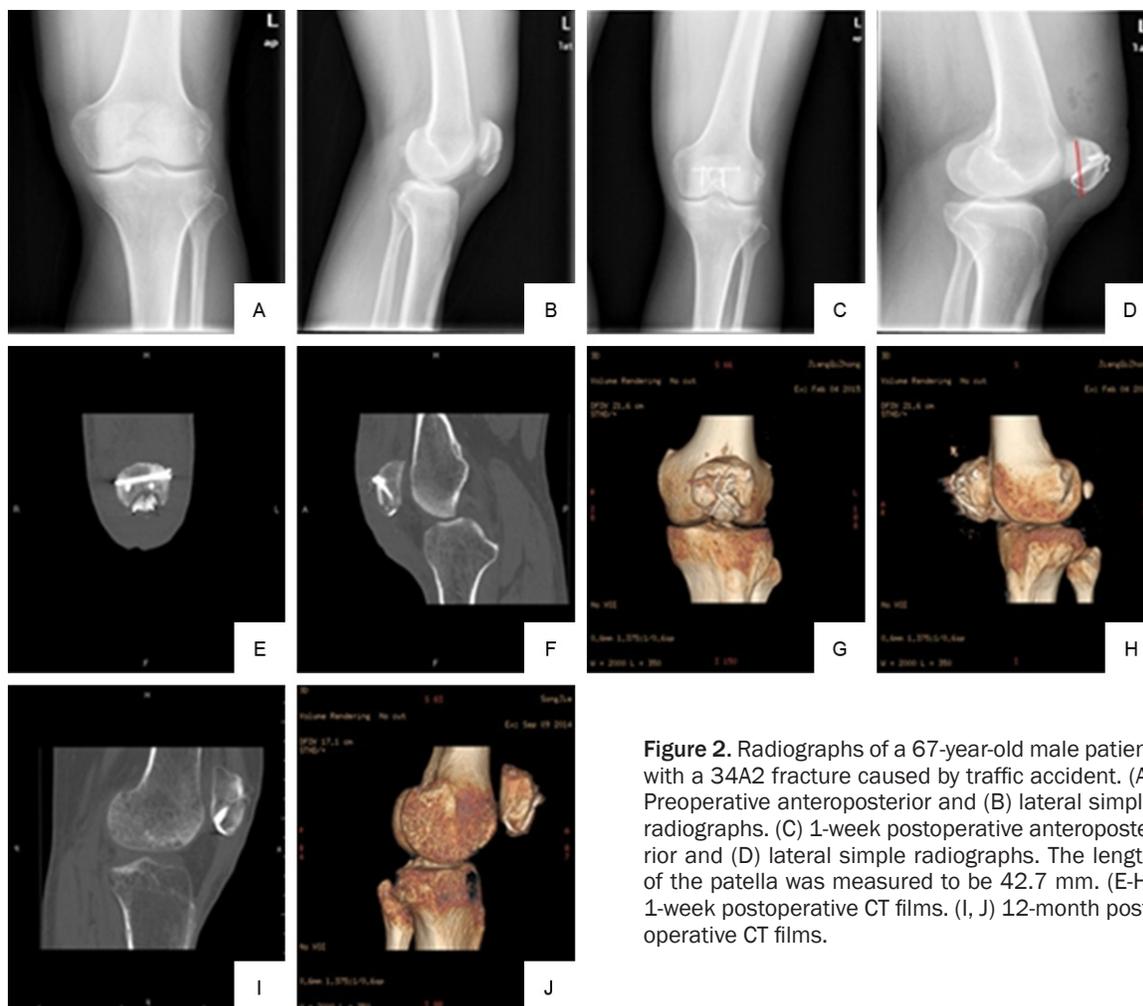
Radiographs of a 67-year-old male patient with a 34A2 fracture caused by traffic accident. (A) Preoperative anteroposterior and (B) lateral simple radiographs. (C) 1-week postoperative anteroposterior and (D) lateral simple radiographs. The length of the patella was measured to be 42.7 mm. (E-H) 1-week postoperative CT films. (I, J) 12-month postoperative CT films.
